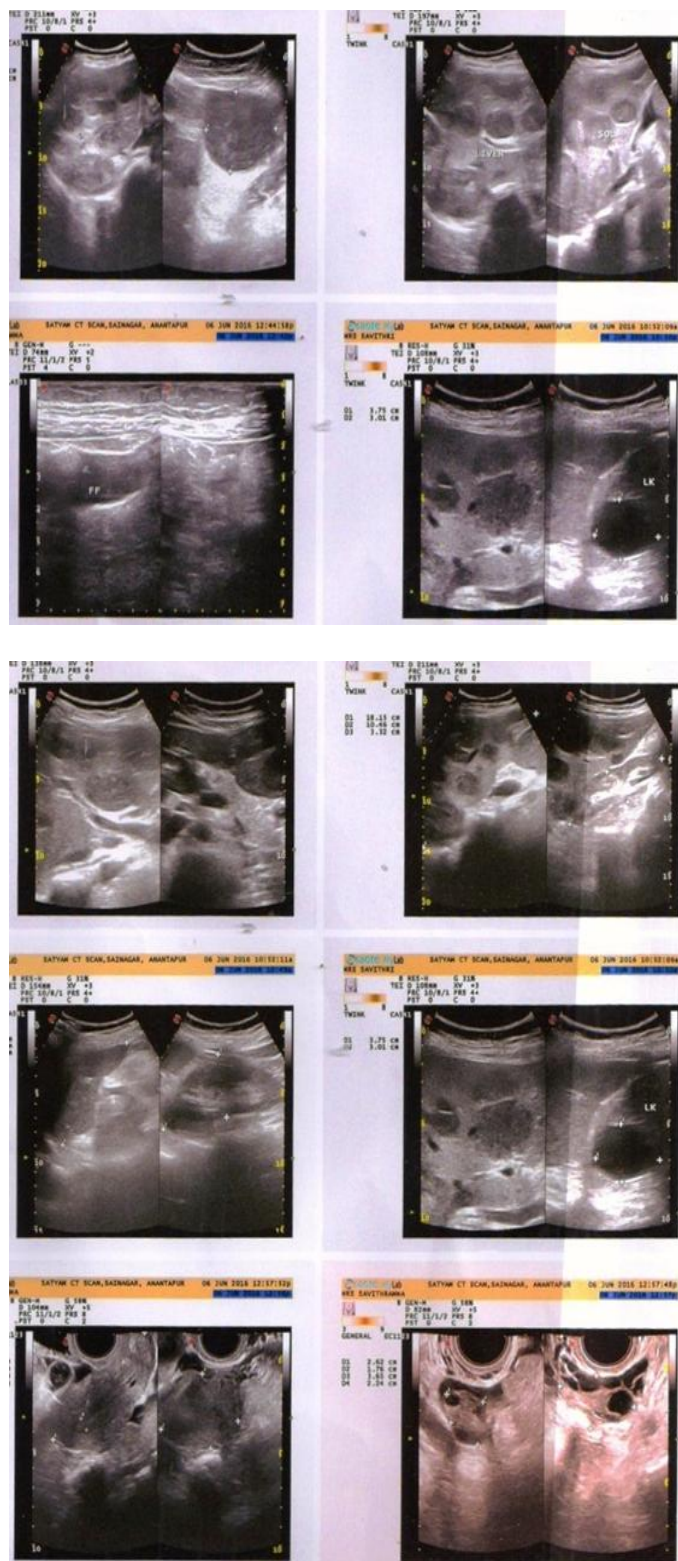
Real-time ultrasonography: Hepatomegaly with multiple hypochoic lesions of varying sizes in both lobes of liver and largest measuring 5.1x5.1cms. Left renal cortical cyst is noted in upper pole measuring 3.7x3.0cms
